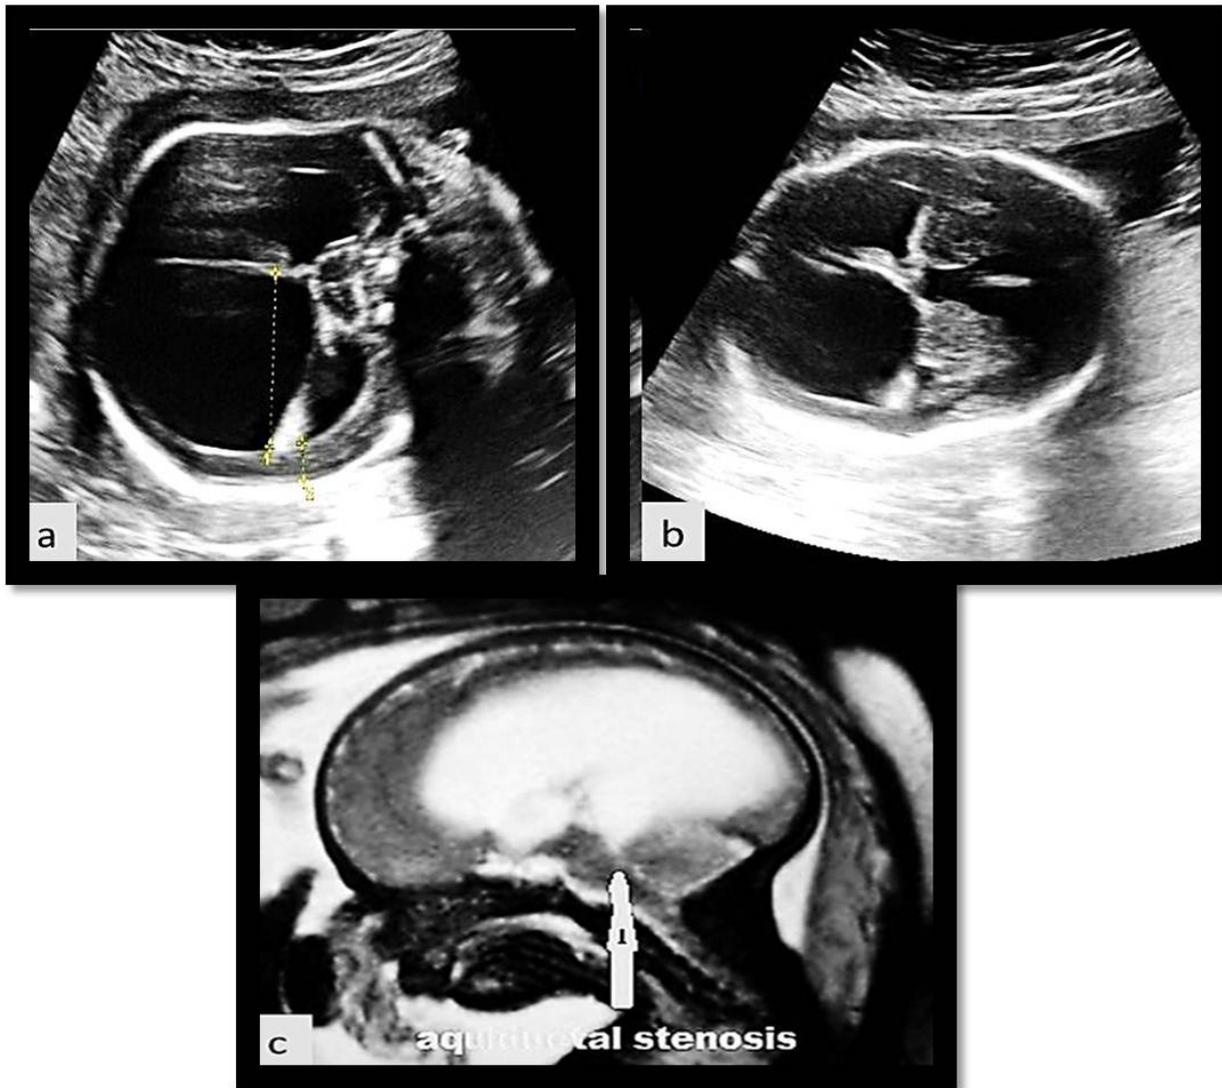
Fetus of 24 weeks GA, (a, b) is U.S (axial & coronal images) showing moderate dilatation of supratentorial ventricular system.(c) Fetal MRI in sagittal plane shows non-communicating hydrocephalus with aqueductal stenosis.
